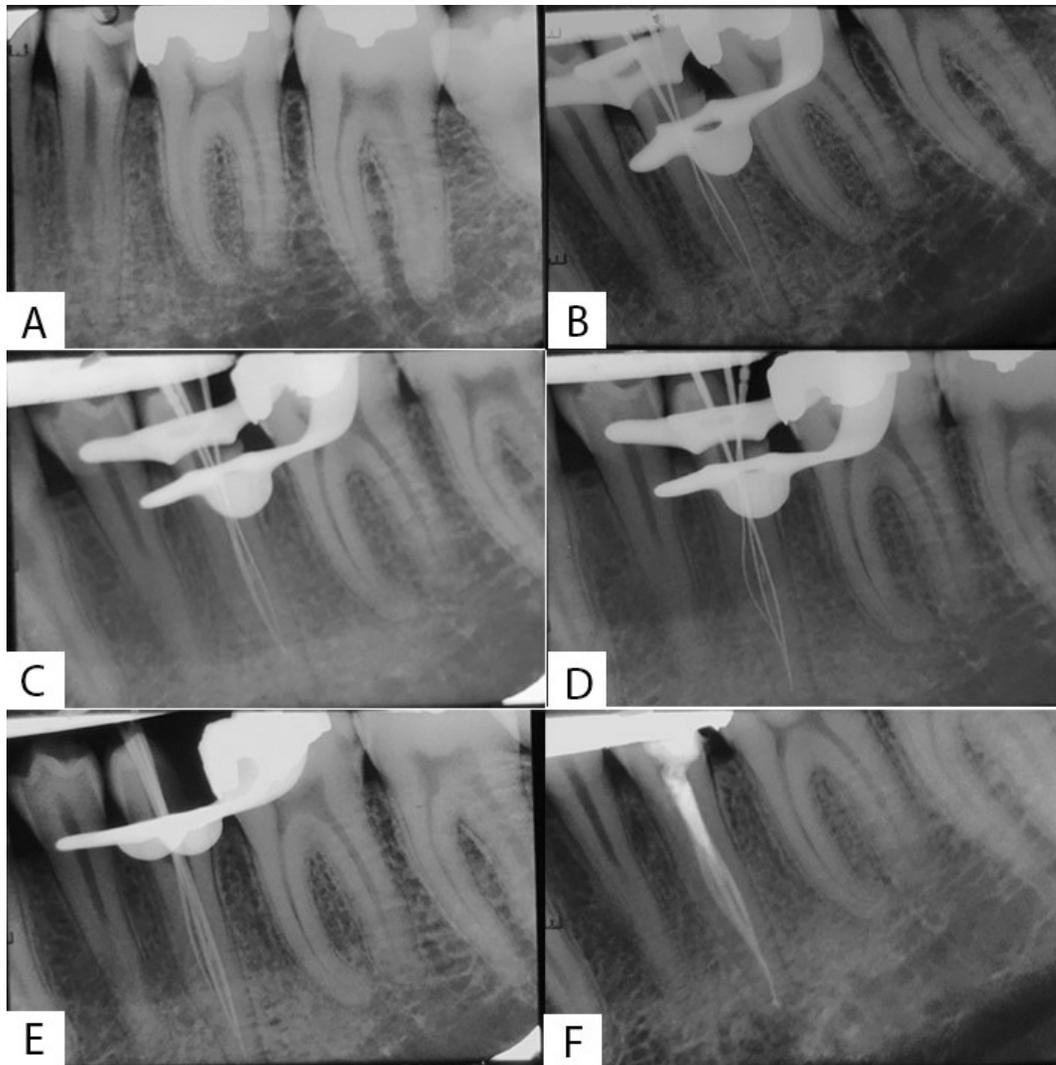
Periapical radiographs of tooth #20; A) The initial radiograph reveals carious disto-occlusal lesion and atypical canal configuration of tooth #20; B) First working length radiograph suggests that there is another canal which is located mesially; C) Unsuccessful attempt to find the third canal; D) The third canal has been found, and the working length is confirmed; E) Master cones confirmation radiograph; F) Post-operative radiograph
